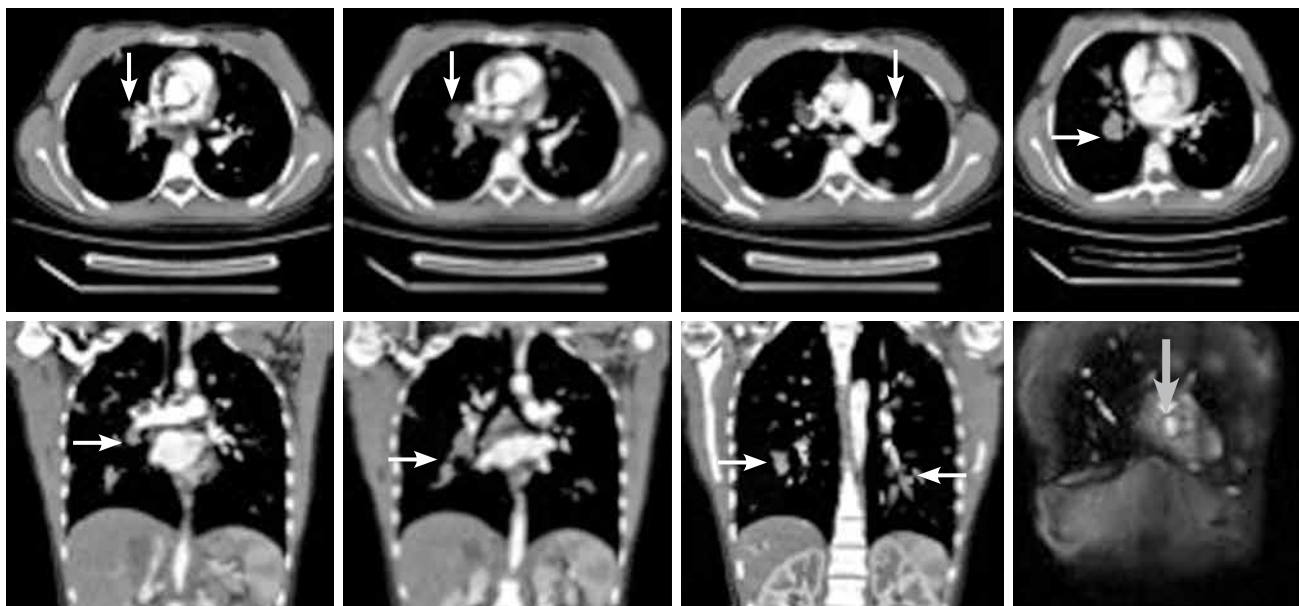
Transverse and coronal contrast-enhanced thoracic computed tomography scans showing bilateral multiple, cystic lesions within major and distal pulmonary artery branches (white arrow). Coronal contrast-enhanced magnetic resonance imaging scans showing a left ventricular cystic mass with a hypointense peripheral rim at T₂-weighted images (gray arrow) consistent with a hydatid cyst.
